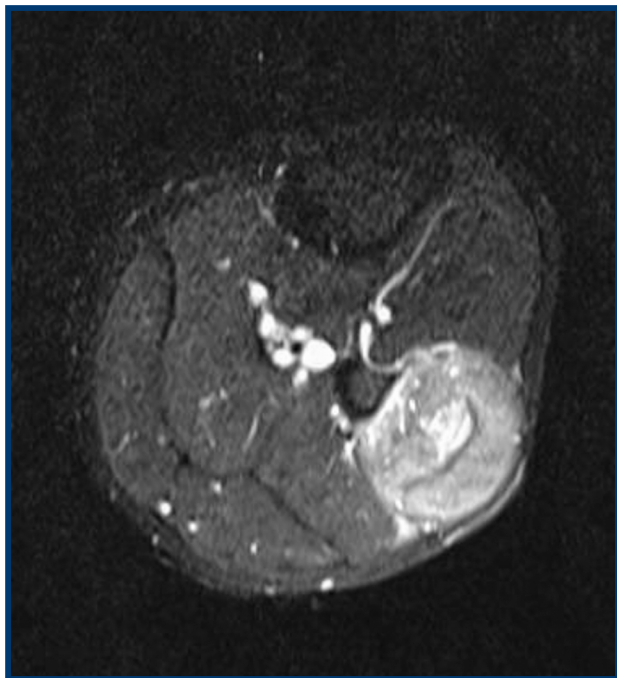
MRI of the left leg. Edema is seen in the peroneal compartment.
